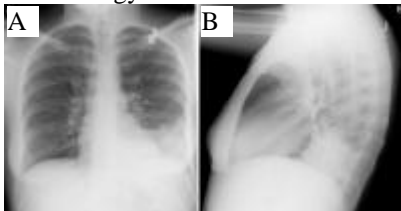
(A) Anteroposterior radiograph from a child with a left lower lobe infiltrate. (B) Lateral radiograph of the same child with a left lower lobe infiltrate
